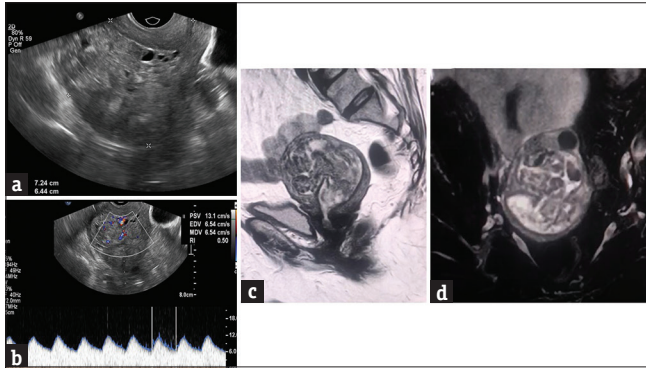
Degenerated leiomyoma prolapsing into the endometrial cavity: Ultrasound is commonly the first examination to be performed, but it has limitations in the characterization of masses. This is why magnetic resonance imaging is helpful in such cases. (a and b) TVS and color Doppler images reveal thick endometrium with Swiss cheese appearance with vascularity not typical pedicle pattern of endometrial polyp and the margins of endometrial cavity are ill defined anteriorly (yellow circle). (c and d) Sagittal and oblique axial T2-weighted images reveal submucosal anterior wall leiomyoma with degeneration prolapsing into the endometrial cavity (orange dashed line) occupying the fundus and body with defect in the continuity of the junctional zone anteriorly (Blue arrow). Seedling intramural anterior wall myoma present in upper body (Red arrow). diffusion-weighted image showed low signal on high B value with apparent diffusion coefficient values 1.6–1.7, suggesting no restricted diffusion-weighted image (T2 SHINE THROUGH): HPE: Degenerated leiomyoma prolapsing into endometrial cavity
